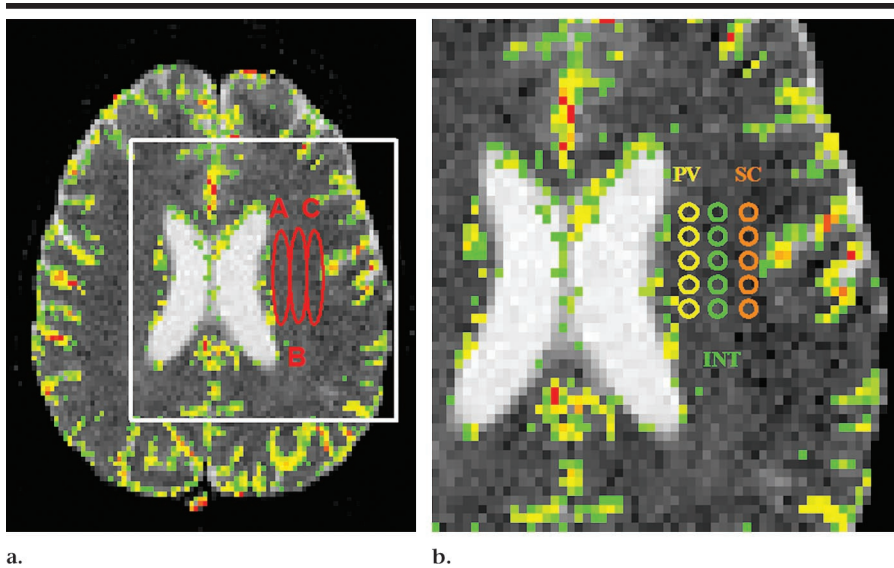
(a) Transverse gradient-echo echo-planar MR image (1,000/54) with CBV map overlay shows the elliptical regions of NAWM that were examined: periventricular NAWM (A), intermediate NAWM (B), and subcortical NAWM (C). In the perfusion color overlay map, areas of no color represent baseline white matter perfusion, green represents threshold gray matter perfusion, yellow represents increased perfusion, and red represents maximal perfusion. This is to ensure that ROIs are placed in the NAWM and lesions and vascular and gray matter structures are avoided. (b) Close-up of area in white box in a. To optimize reproducibility, five measurements were obtained from each of the three locations. These five CBV, CBF, and MTT measurements were recorded and averaged. ROIs were fixed in size (radius = 1 image pixel, 1.8 mm) and placed to avoid arterial or venous structures in NAWM, particularly in the periventricular and subcortical regions. Hence, each ROI has an in-plane resolution of 2 pixels. The location of ROI placement was at the same section position in patients with RR-MS and in control patients at the level of the ventricles. The ROIs were placed after visual coregistration with the transverse T2-weighted and fluid-attenuated inversion recovery MR images to ensure that lesions were not included in the ROI. INT = intermediate NAWM, PV = periventricular NAWM, SC = subcortical NAWM.
